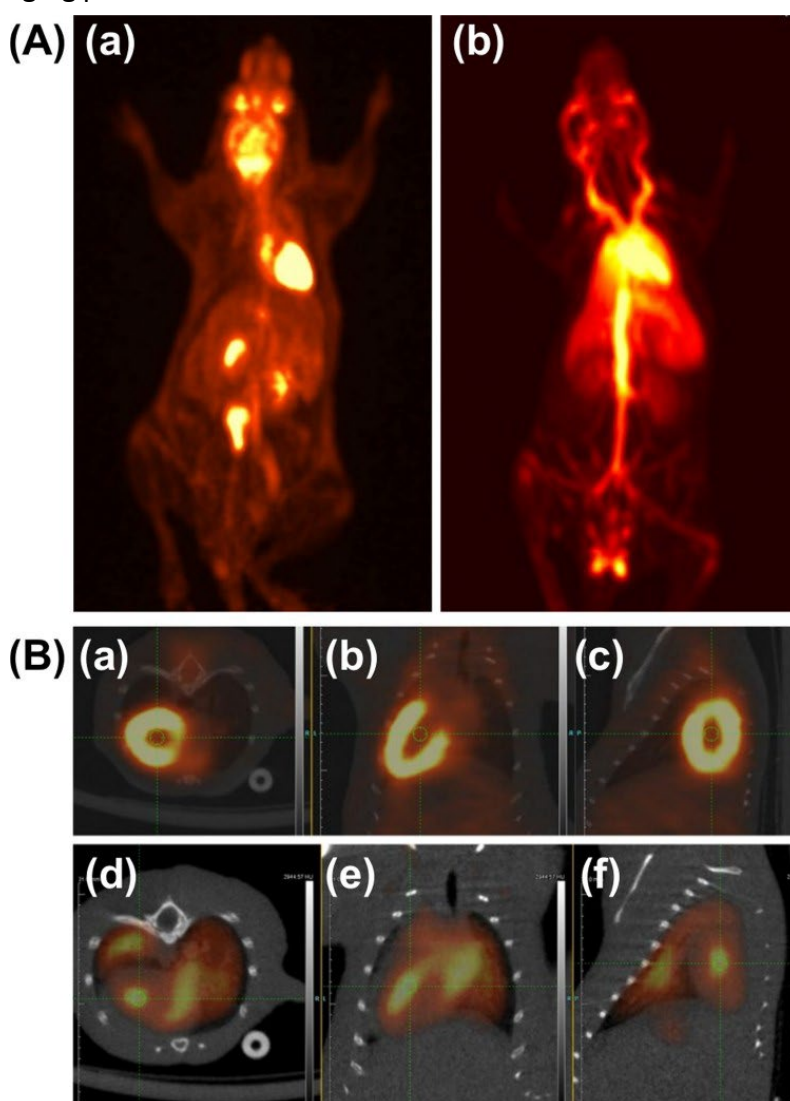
The use of ^{18}F -fluorodeoxyglucose (FDG)-labelled erythrocytes as an *in vivo* imaging probe.
